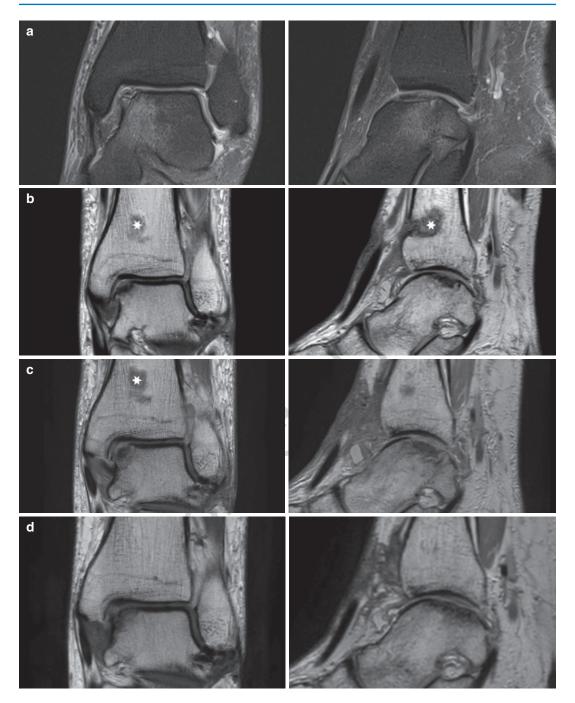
An example of slow remodeling of the biological inlay of medial talus. MRI evaluation of the left ankle of a 48-year-old female regarding the stepwise remodeling of the subchondral lamina and chondral surface: (a) osteochondral defect grade III of the medial aspect of the talar dome, preoperatively; (b) biological osteochondral inlay (asterisk indicates donor site of a spongiosa bone graft), 3 months postoperatively; (c) 6 months postoperatively, a border of subchondral lamina and chondral surface are clearly visible, bone edema slightly decreased;
